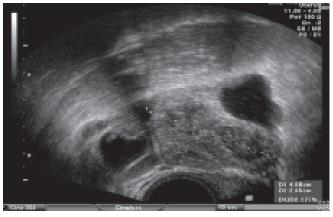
Transvaginal ultrasound of a complex adnexal mass in a patient with positive pregnancy test. Note tubular structure with solid part measuring 4.6 x 2.7 cm
